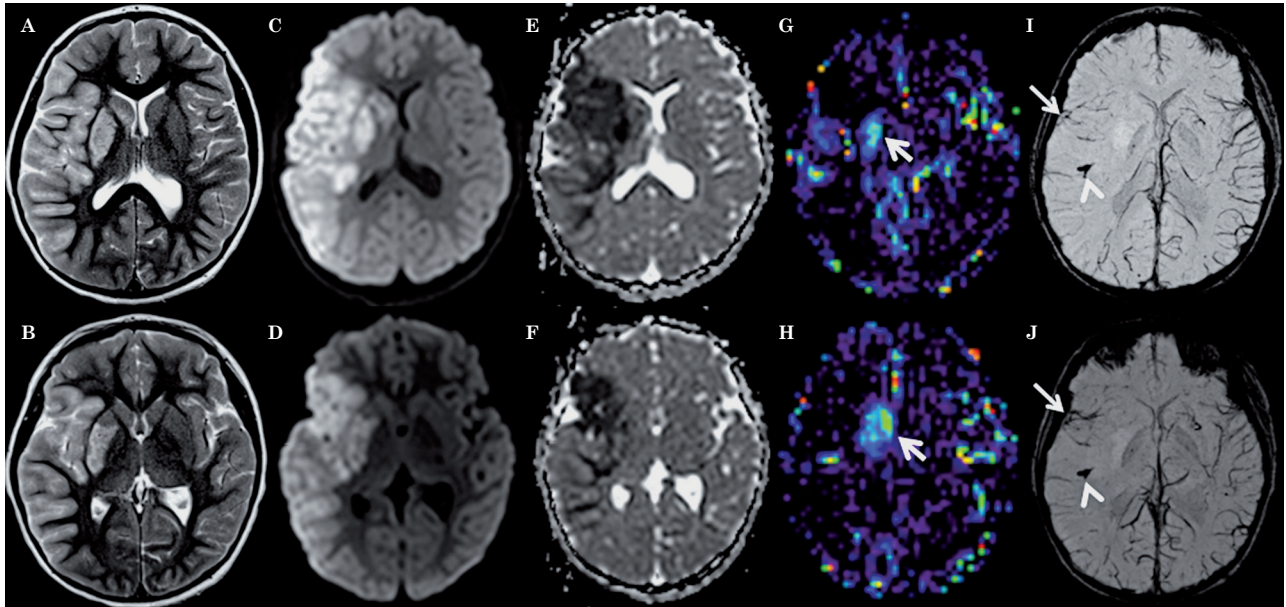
Axial T2-weighted (A,B), trace of diffusion (C,D), ADC maps (E,F), CBF-ASL maps (G,H) and minIP-SWI images (I,J) 8 hours after onset of symptoms show T2 hyperintense signal abnormalities and restricted diffusion (hyperintense signal abnormality on C,D with matching low ADC values on E,F) involving the cortex as well as subcortical and deep white matter within the right MCA territory as well as right putamen and caudate nucleus. Restricted diffusion in the anterior tip of the right temporal lobe and insula matches the territory drained by SWI hypointense sulcal veins (arrows on I,J). The rest of the right MCA territory appears less affected on ADC maps and the sulcal veins draining this territory appear less prominent and especially less SWI hypointense suggesting lower oxygen extraction fraction. In these parts of the right MCA territory, CBF-ASL maps appear symmetrical to the contralateral MCA territory suggesting relative normal perfusion. The veins draining the right anterior basal ganglia are less SWI hypointense matching increased absolute CBF on the ASL map demonstrating hyperperfusion (arrows on G,H). Additionally, the minIP SWI images demonstrate thrombus in the M2 segment of the right MCA with susceptibility artifacts along the course of the vessel (arrowheads in I,J).
